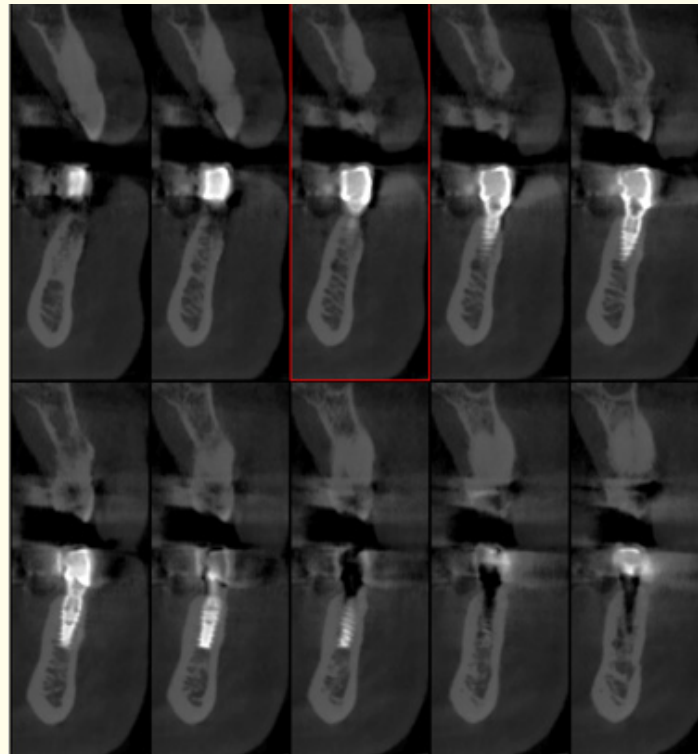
One year post-op CBCT x-ray control shows the perfect implant integration and the buccal bone plate reestablishment.
